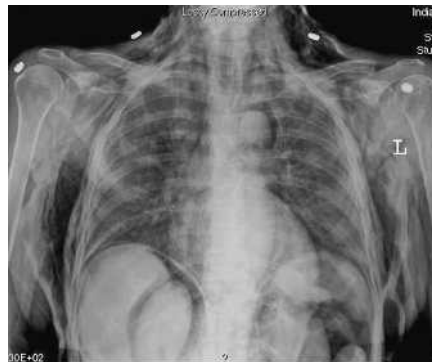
A chest radiograph after the endoscopy showed pneumoperitoneum and pneumomediastinum, with extensive subcutaneous emphysema surrounding the chest wall bilaterally, extending into the neck region.
